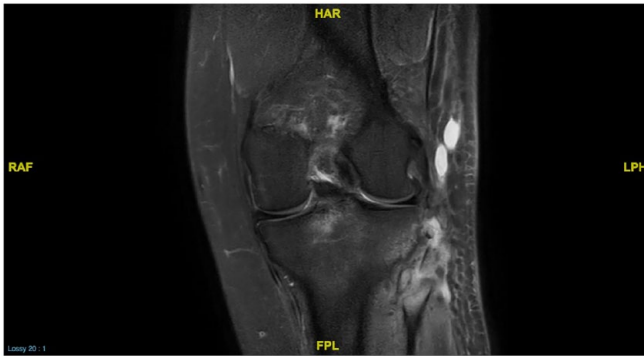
Magnetic resonance imaging coronal T2-weighted image showing an arcuate fracture with avulsion of the fibular collateral ligament.
